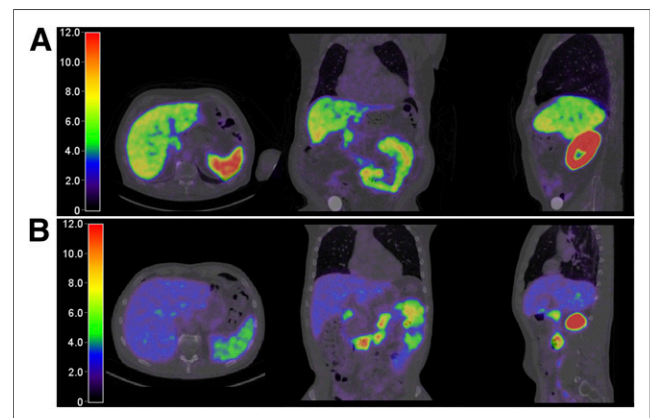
Heterogeneity of ^{68}Ga -PSMA uptake in liver. (A) Patient with liver uptake 1.2 SDs above population average (SUV_{mean} , 6.82; SUV_{max} , 8.96). (B) Patient with liver uptake 1.2 SDs below average (SUV_{mean} , 2.78; SUV_{max} , 3.62). Images with identical SUV scaling.
